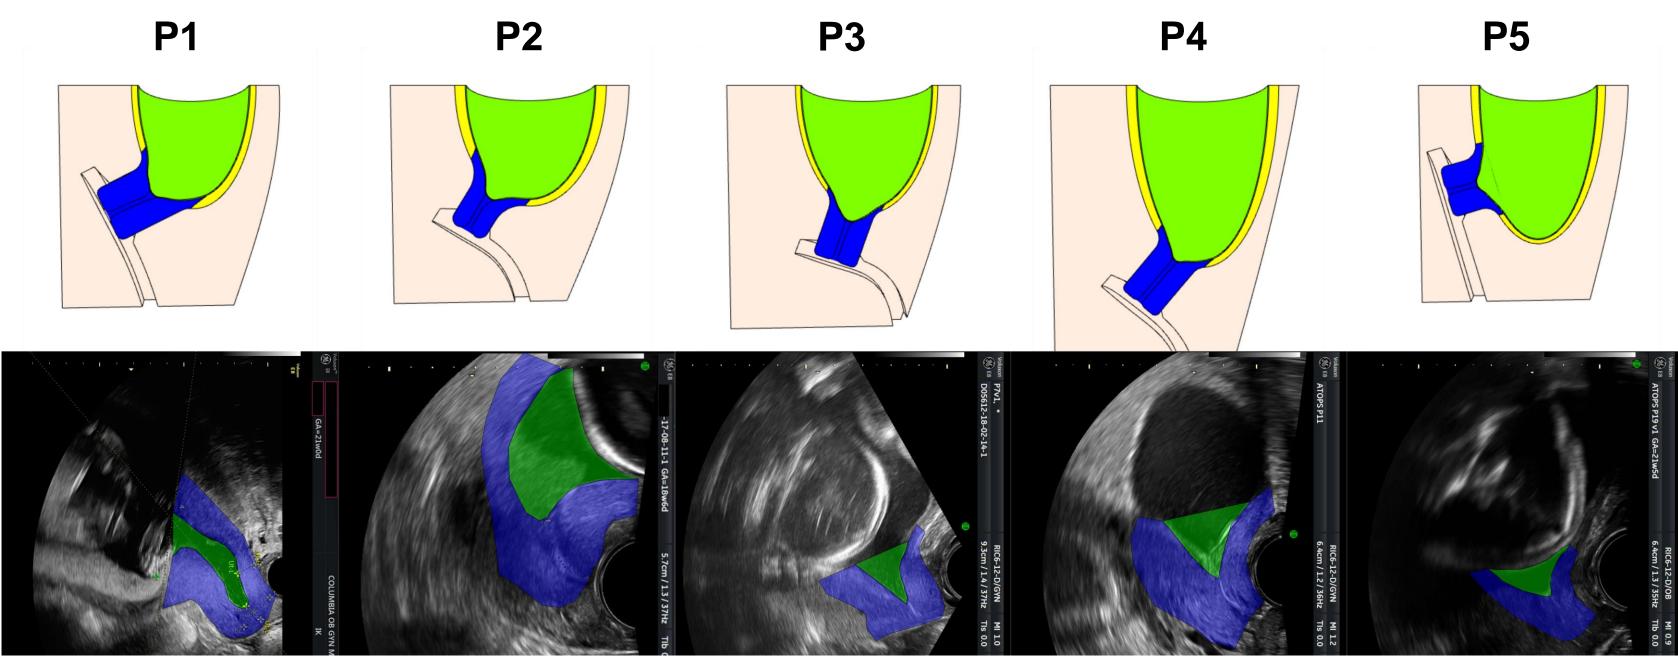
Top row is final funnel shape achieved by model, and bottom row is funnel shape observed in ultrasound (funnel in green, cervix in blue). Model is able to capture funnel shape will for patients with V-shaped funnel (patients 3-5), but not able to capture more complex funnel shapes (patients 1-2).
